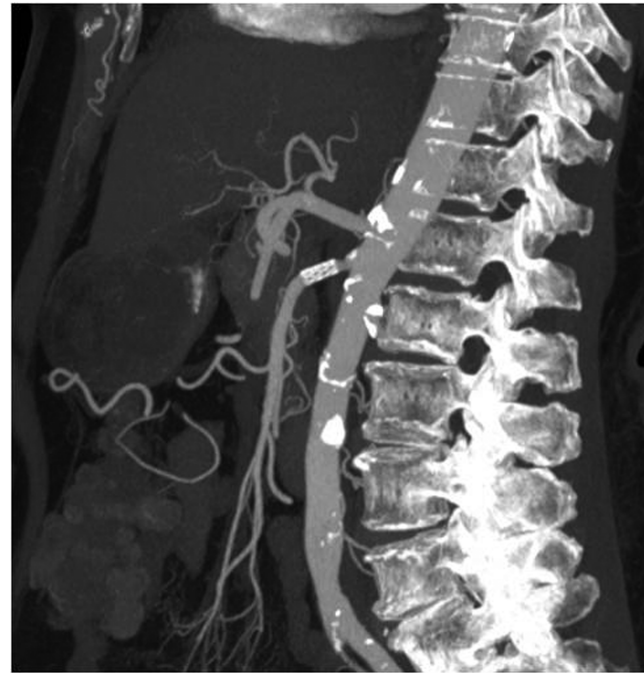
Computed tomographic angiogram showing a stent in a superior mesenteric artery. Mesenteric artery stents are being used with increasing frequency as an alternative to bypass for treatment for chronic visceral ischemia in higher-risk patients.
